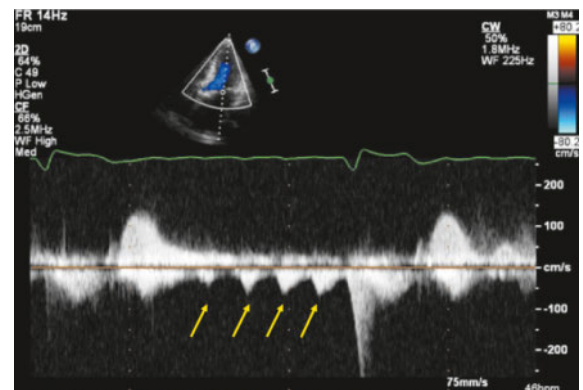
CW-Doppler spectrum showing repetitive short-lasting signals corresponding to diastolic mitral regurgitation in a patient with atrial flutter as well as third-degree atrioventricular block. There is also systolic mitral regurgitation.
